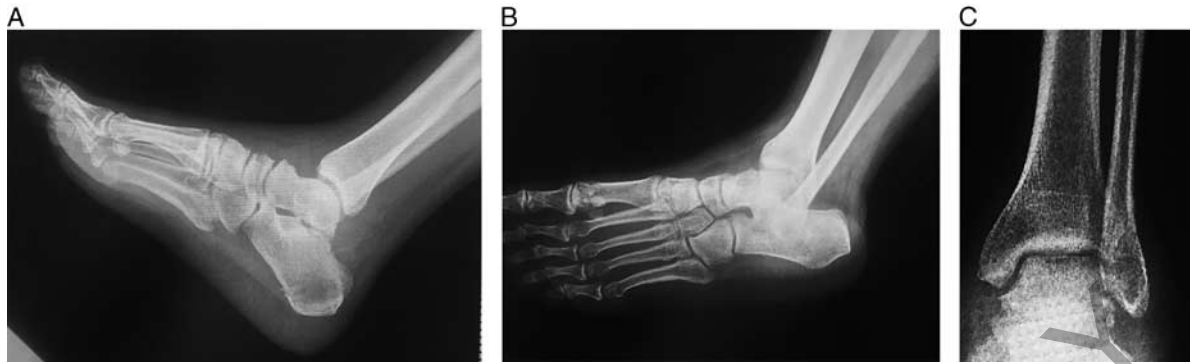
Lateral (A), oblique (B), and anteroposterior radiographs (C) at 1-year follow-up.
